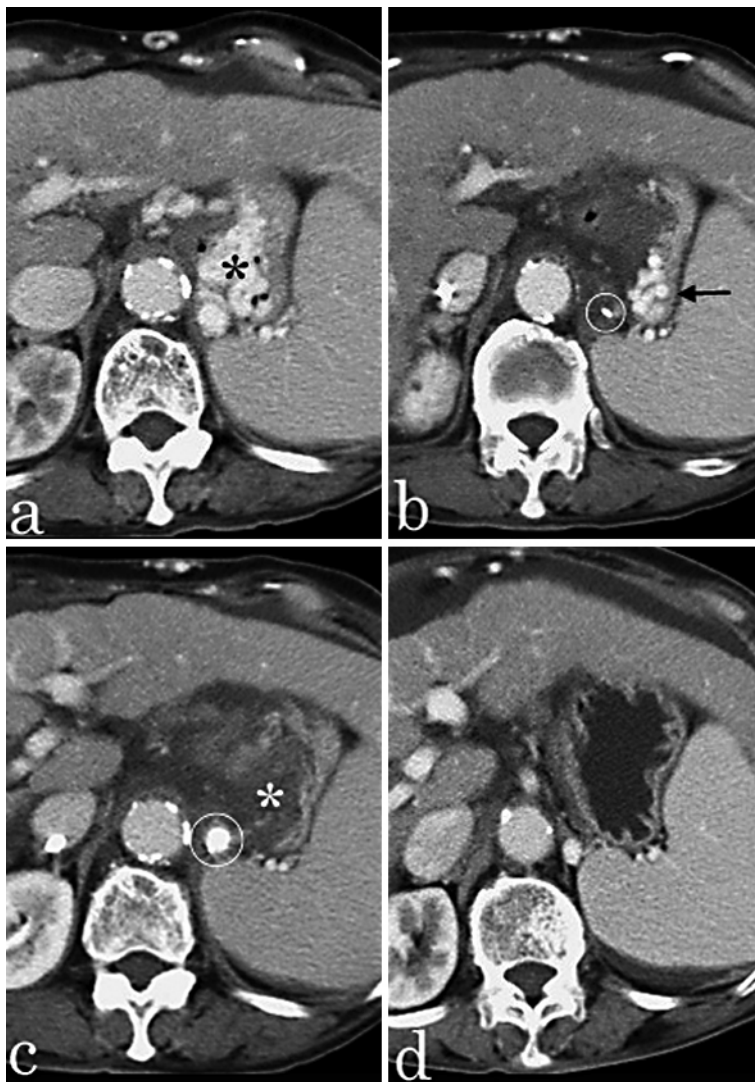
Contrast-enhanced CT scans showing gradual disappearance of gastric varices after two BRTO procedures. a Large varices (asterisk) are seen in the stomach before BRTO. b Residual varices (arrow) are seen in the lateral portion of the stomach after the first BRTO. The microcatheter tip (circle) is in the gastroduodenal shunt close to the varices. c Complete thrombosis of the varices (asterisk) is achieved after the second BRTO. The sclerosant with contrast medium (circle) is detected in the gastroduodenal shunt. d No gastric varices are visible 3 months after the BRTO procedures.
